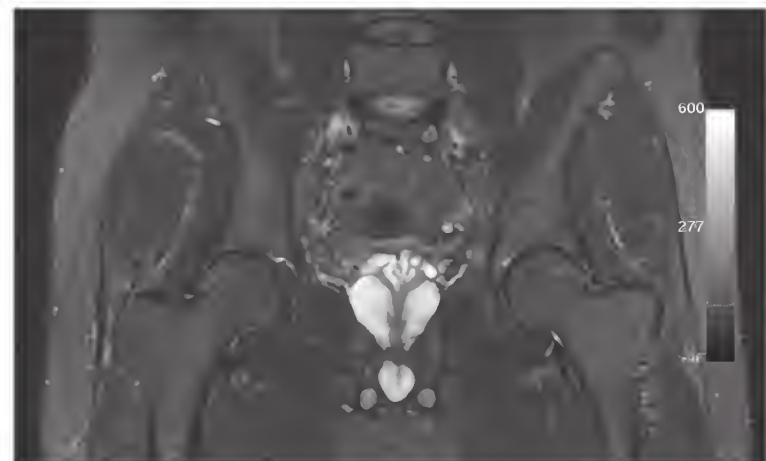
Baseline magnetic resonance image showing increased signal in the left femoral head in a 30-year-old woman with idiopathic transient osteoporosis of the hip at 3 months postpartum.
